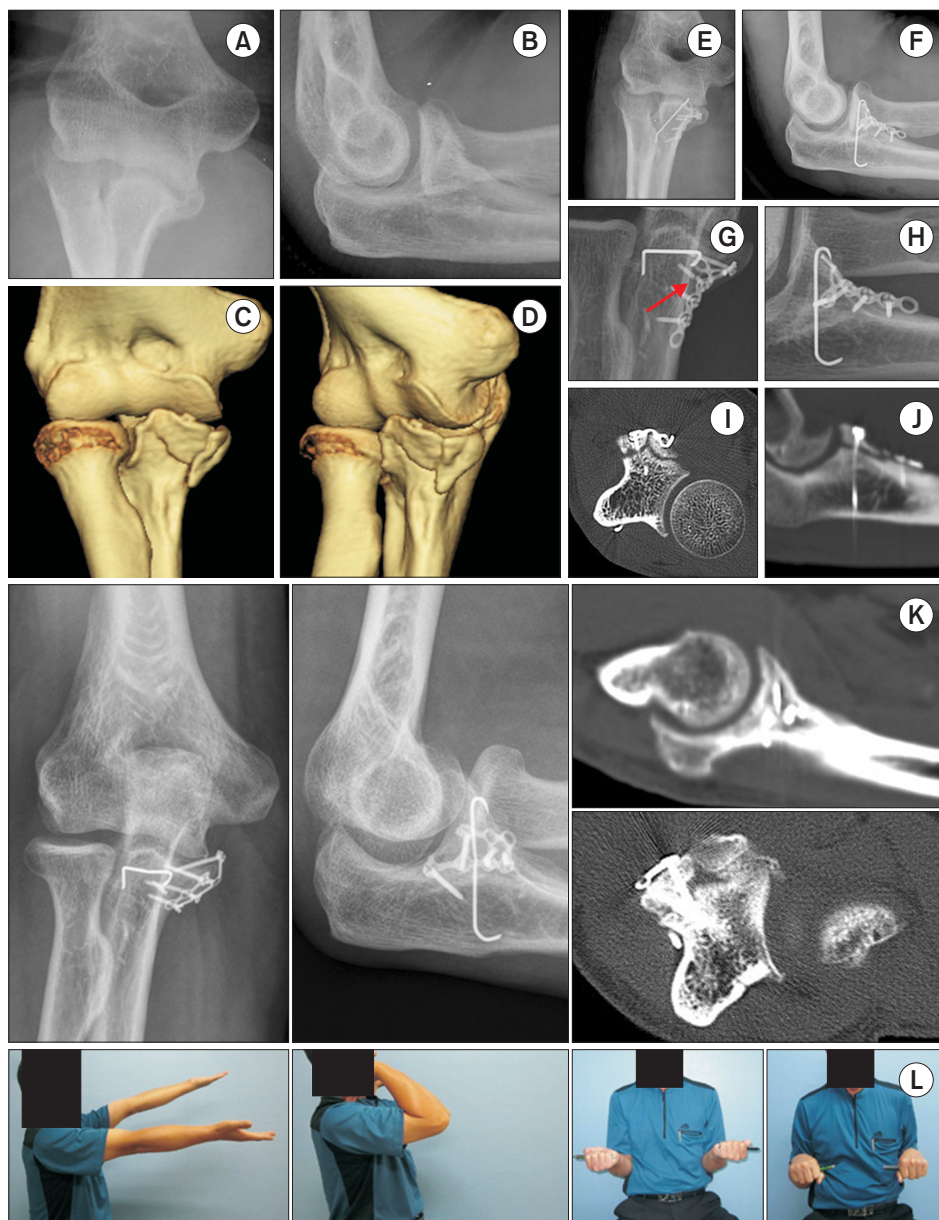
(A-D) A 61-year-old male patient was diagnosed with a type II coronoid process fracture (anteromedial facet type). (E, F) Fixation was done with a Kirschner wire and an additional buttress plate. Appropriate reduction and fixation were confirmed. (G, H) Radiographs obtained 16 weeks after surgery. One screw breakage was shown (red arrow). (I, J) Nonunion of the fracture site was checked on the computed tomography image. (K) Reoperation was done with the same technique using an autogenous iliac bone graft. Bony union was checked at 5 months after the revision surgery. (L) Good functional outcome was shown with 138° of arc of motion (Mayo Elbow Performance Score, 85).
